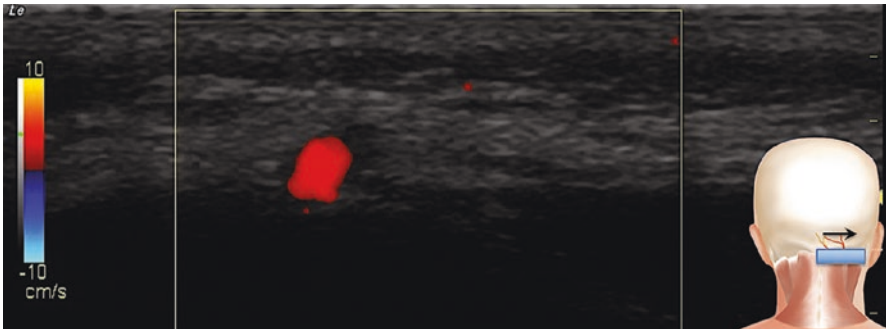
Doppler showed the occipital artery which is in the same fascia plane with the greater occipital nerve. (Reprinted with permission from Philip Peng Educational Series)
